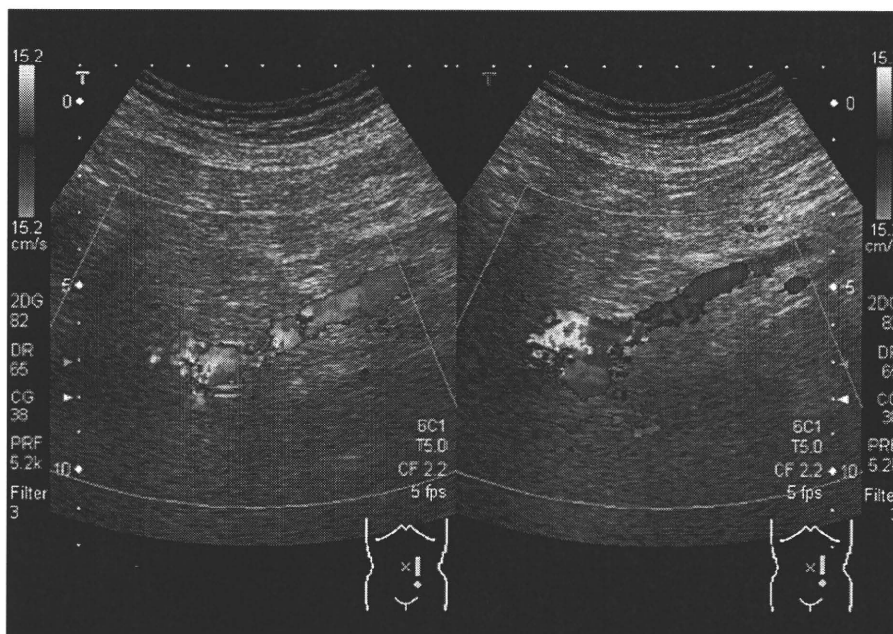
Color Doppler (72-year-old man with medium-grade gastric fundal varices [F2]). The sagittal plane of the color Doppler sonogram showed gastrorenal shunt with a to-and-fro appearance.
